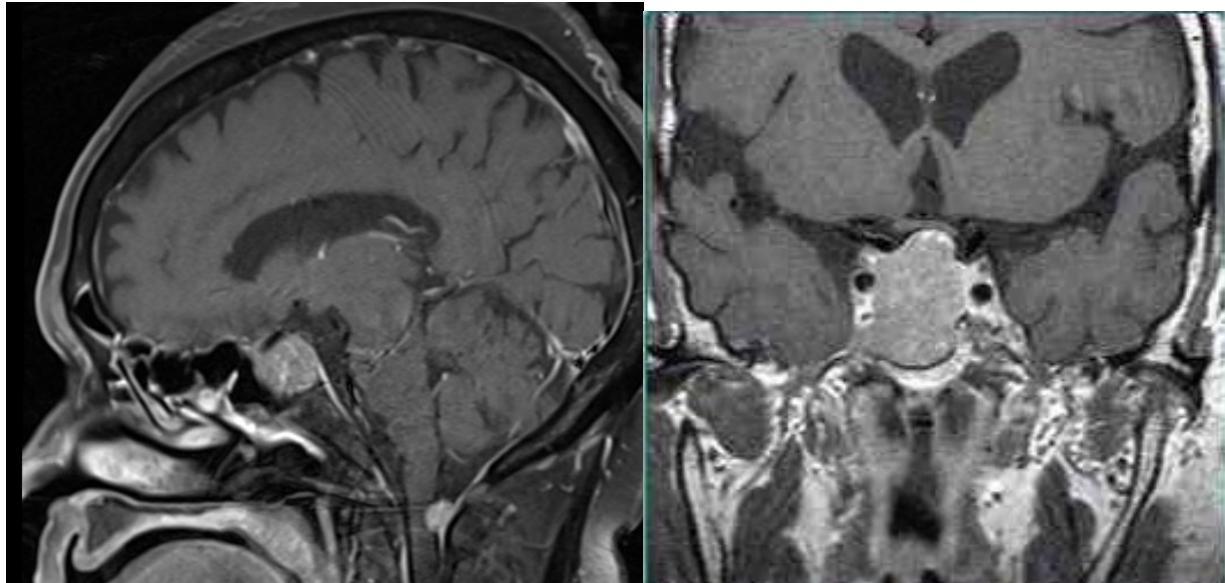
sagittal T1 MRI of the brain with contrast
